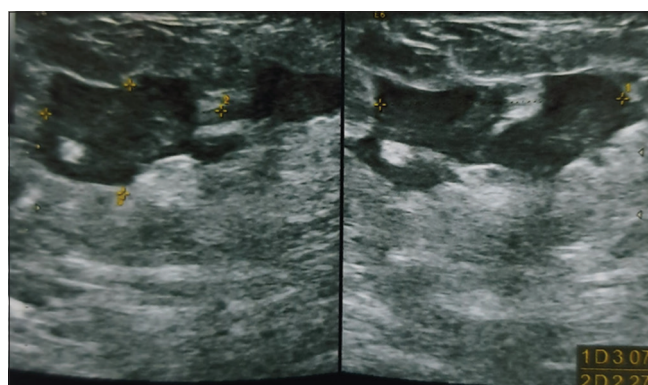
Ultrasonography of breast revealed hypoechoic lesion with collection suggestive of abscess
